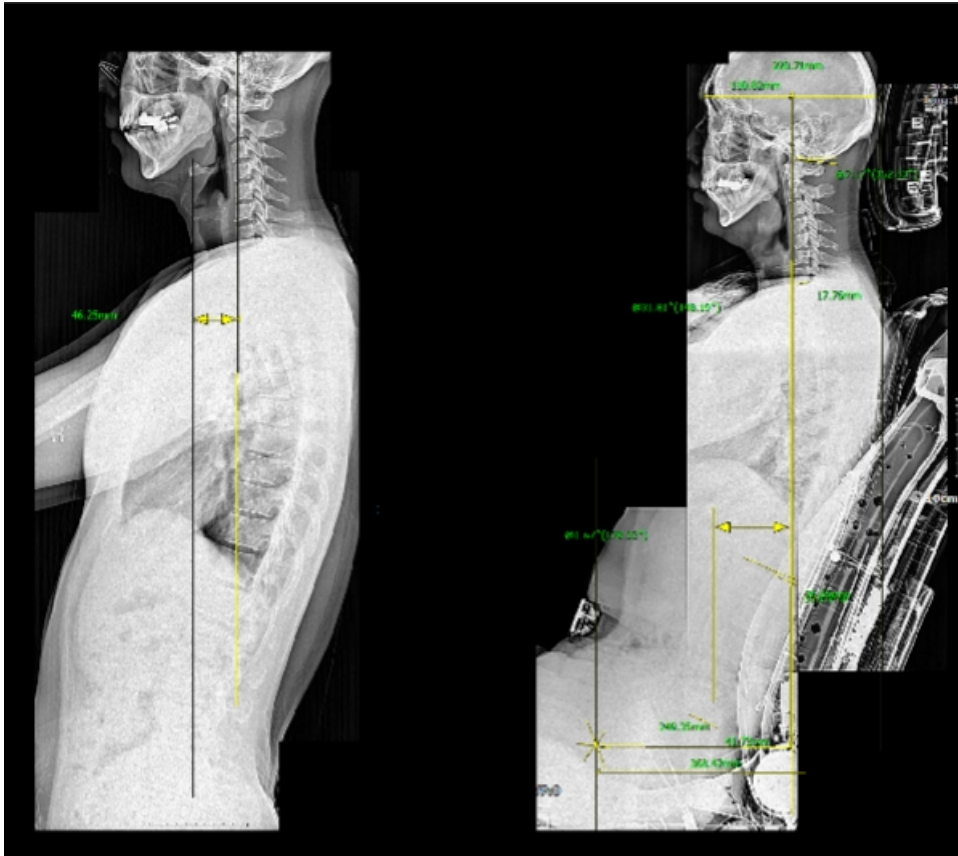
Comparison of standing upright and sitting on an automotive seat by radiographic assessment.
